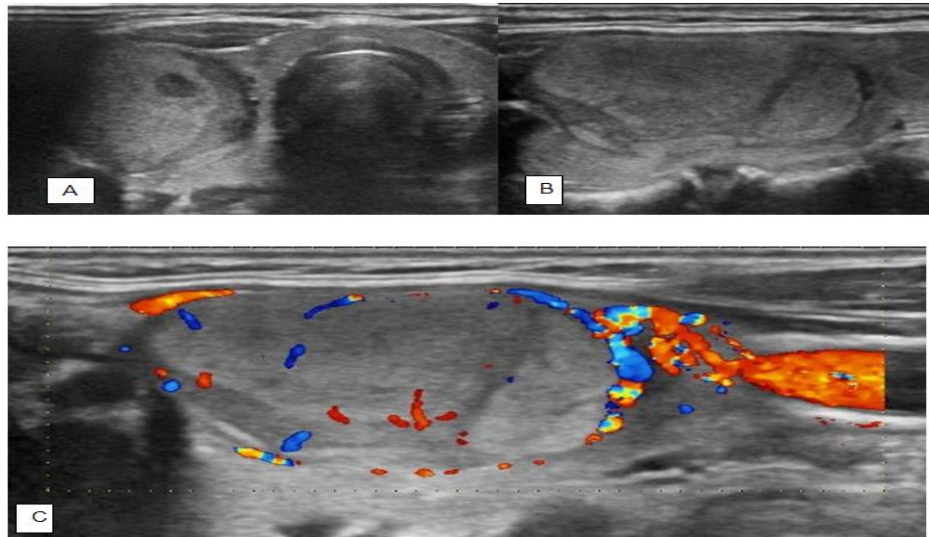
In a 40 years old female A. Axial section of the right thyroid lobe showing a well-defined, solid, heterogeneously hyperechoic nodule. B. The longitudinal section of the same nodule shows its wider than tall shape and smooth margins. C. On colour Doppler, the nodule shows internal and peripheral vascularity
